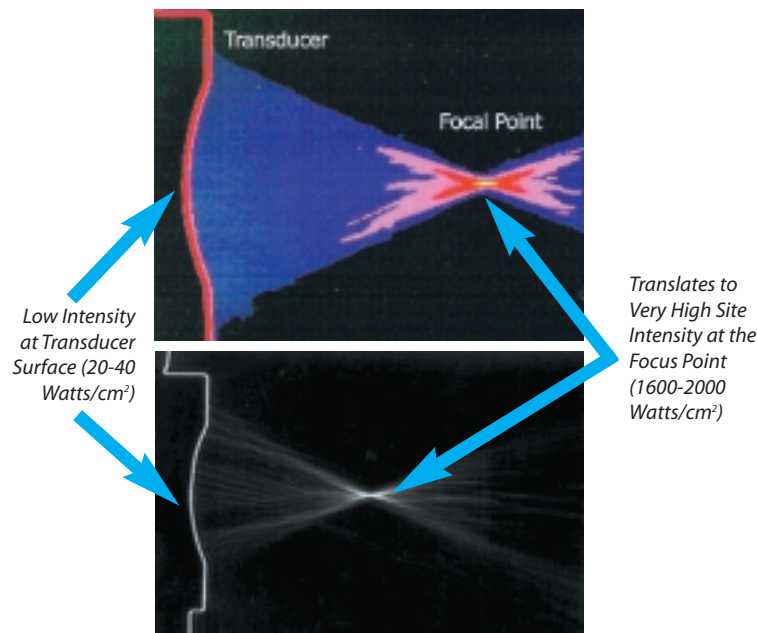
Focusing of Transrectal Ultrasound to Create Lethal Heat to Malignant Tissue.*
